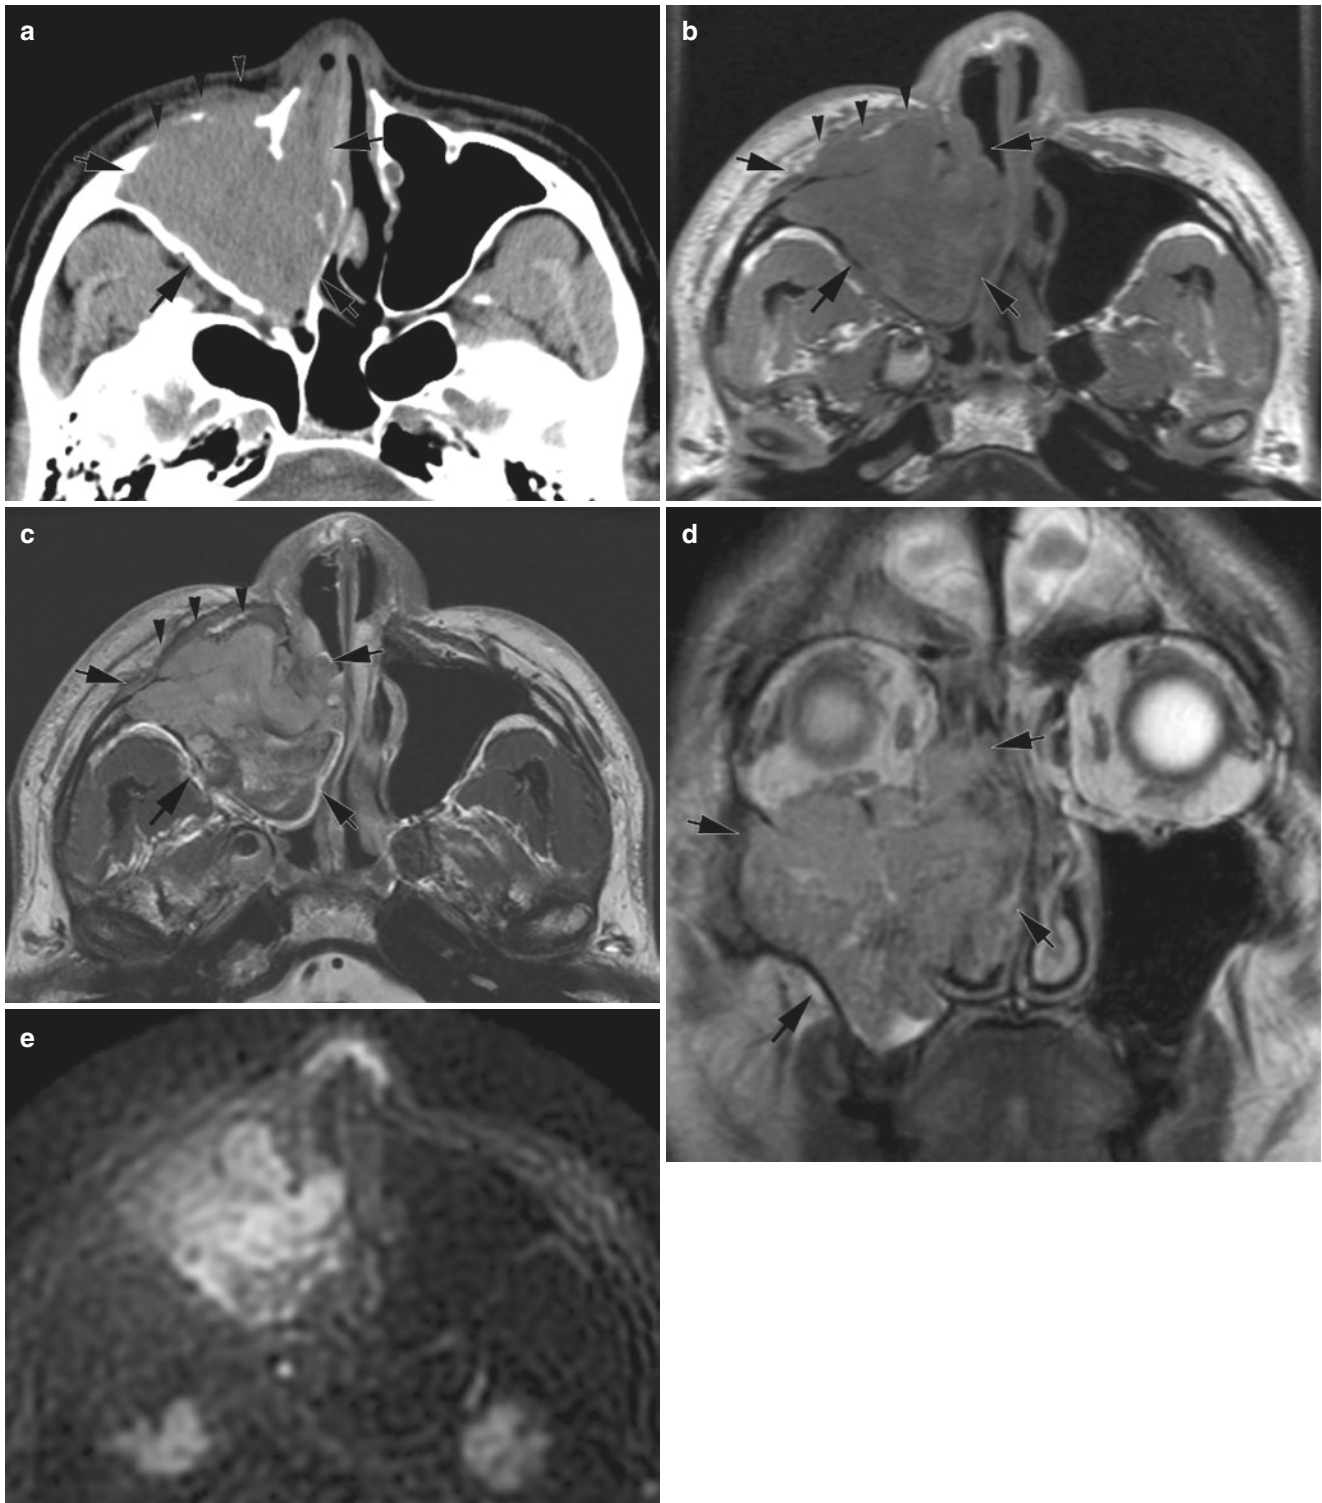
Undifferentiated carcinoma of the maxillary sinus. (a) Bone CT. (b) Axial T1-weighted image. (c) Axial Gd-enhanced T1-weighted image. (d) Coronal T2-weighted image (Posterior to b). (e) Diffusion-weighted image. CT (a), T1-weighted (b), and contrast enhanced T1-weighted (c) images show a solid mass occupying the right maxillary sinus, with destruction of the anterior wall bone (arrowheads).
